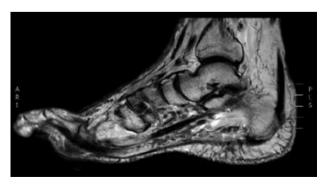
Magnetic resonance imaging shows 2nd right metatarsal joint osteomyelitis.
